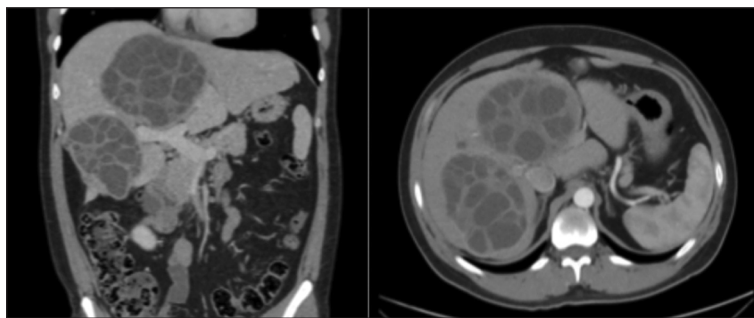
World Health Organization Informal Working Group on Echinococcosis classified hydatid cysts based on ultrasonographic imagery as active (CE1, CE2), transitional (CE3a, CE3b), and inactive (CE4, CE5) cysts. During the stages CE2 and CE3b, surgical treatment is indicated. CE2 hydatid disease according to ultrasonography larger than 15 cm in liver segments 4 and 6 in the preoperative period. Computerized tomography image of CE2 disease.
